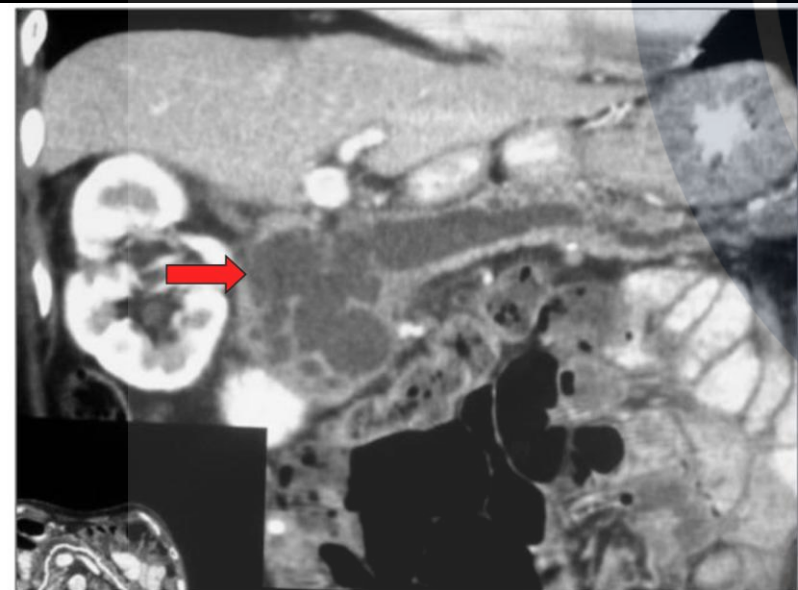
Curved reconstructed CT image in the course of the dilated pancreatic duct shows a typical case of main duct IPMN (arrow).
